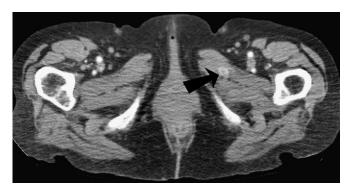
A 70-year-old woman with a history of renal cell carcinoma 6 years earlier. Axial reconstruction of contrast-enhanced computed tomography shows hypervascular metastatic deposit consistent with renal cell metastasis in the left-sided adductor muscle (black arrow).
